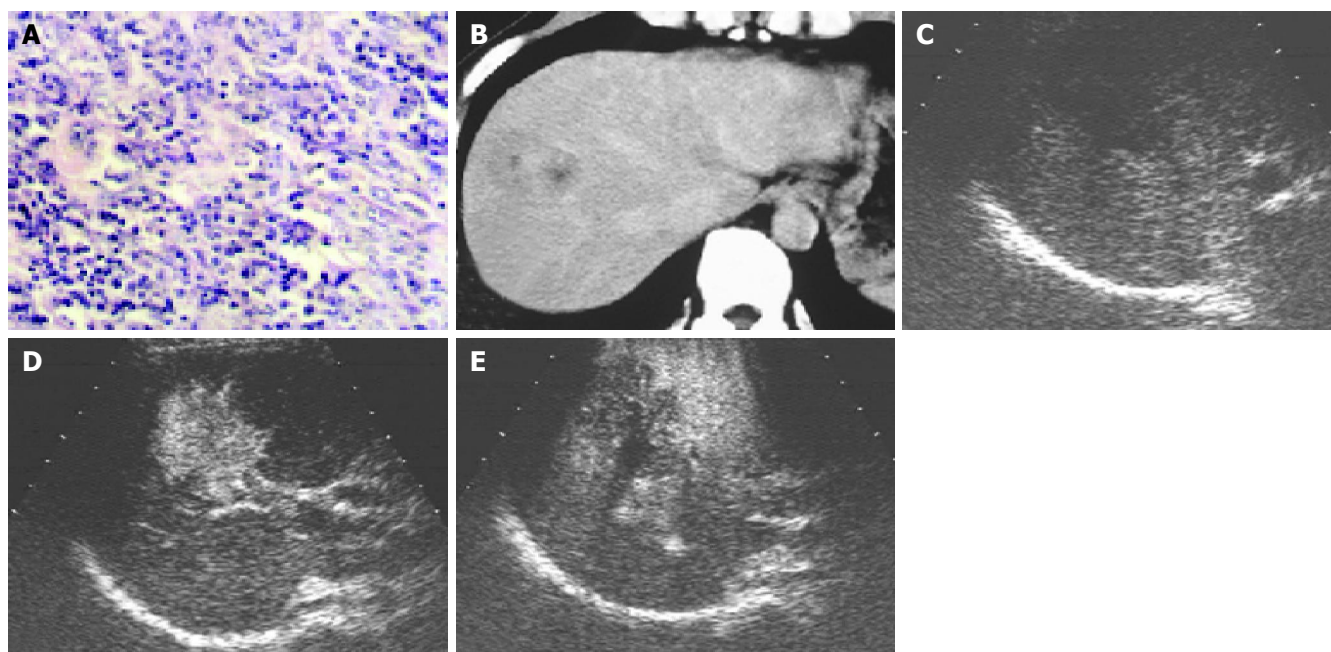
A: hepatocellular carcinoma; B: heterogenous high attenuation on contrast-enhanced CT; C: low echo on B-mode image; D: the hypervascularity
